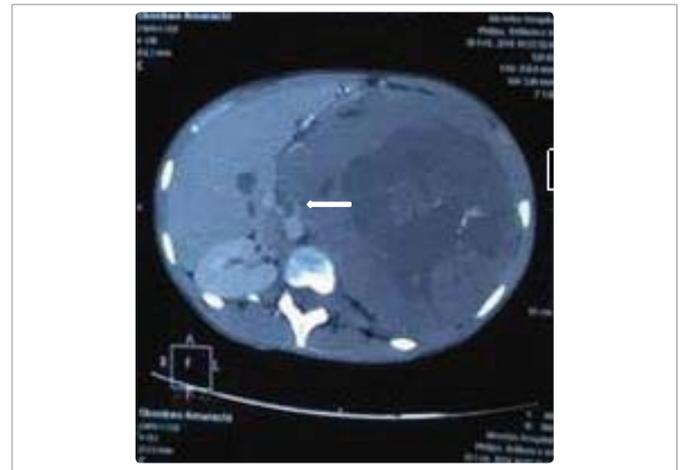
Coronal helical image slice Computed Tomography (CT) scan of the abdomen of one of the patients. CT scan showed a left Wilms' tumor (white arrow) affecting the upper pole and pushing the rest of left kidney to the periphery.
